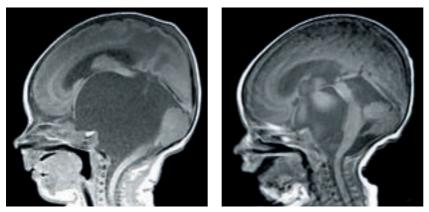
Sagittal T1 MRI images are shown from a patient with a prepontine (suprasellar) before (left) and after (right) endoscopic fenestration.
